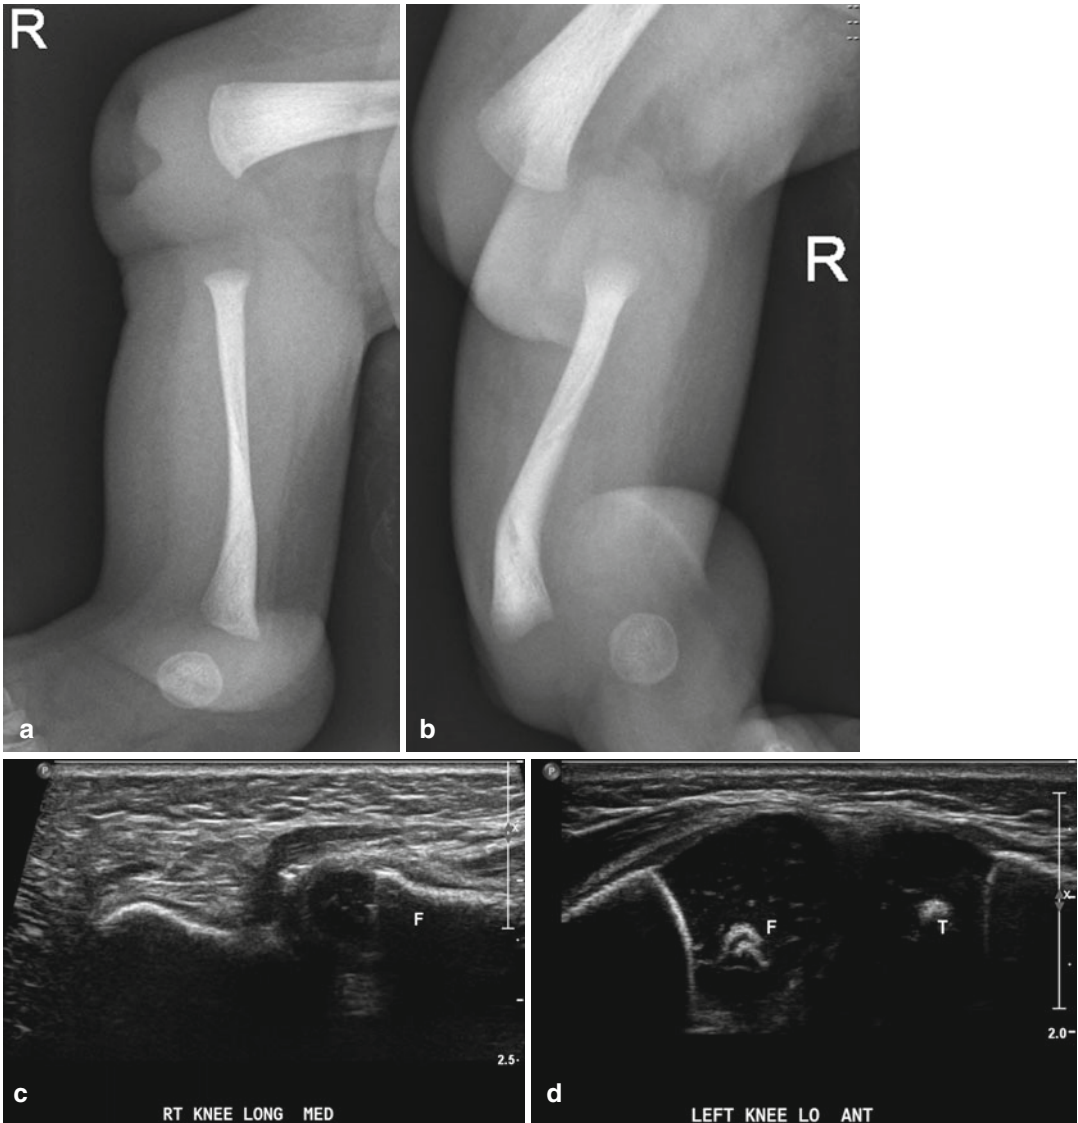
(a, b) AP and lateral radiographs of the knee of a child with complete tibial hemimelia (Jones type 1a). (c, d) An ultrasound demonstrating no cartilaginous
